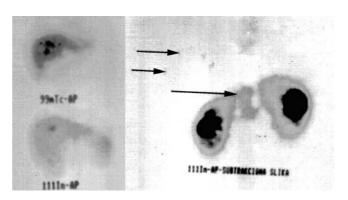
a) Planar radiocolloid scintigraphy anterior view shows almost physiological shape of the liver with almost physiological distribution of radiopharmaceutical in the right lobe, with absent accumulation in the lower part of the left liver lobe; b) Immunoscintigraphy (INDIMACIS 19-9) anterior view in the same patient revealed physiological shape of the liver with accumulation of the radiopharmaceutical in the lower part of the left liver lobe; c) resulting subtraction scintigram, anterior view, shows very small metastases of colorectal carcinoma (15–18 mm) in the upper part of the right liver lobe, interlobar indent and one larger metastases in the region of the lower part ogf the left liver lobe and abdominal lymph nodes.
